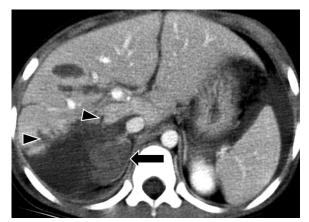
Bare area hepatic injury. Contrast-enhanced CT scan shows multiple lacerations (arrowheads) and a parenchymal hematoma that extend into the bare area of the liver, resulting in retroperitoneal hematoma. Note the hemorrhagic fluid surrounding the IVC and the associated hematoma in the right adrenal gland (arrow).
